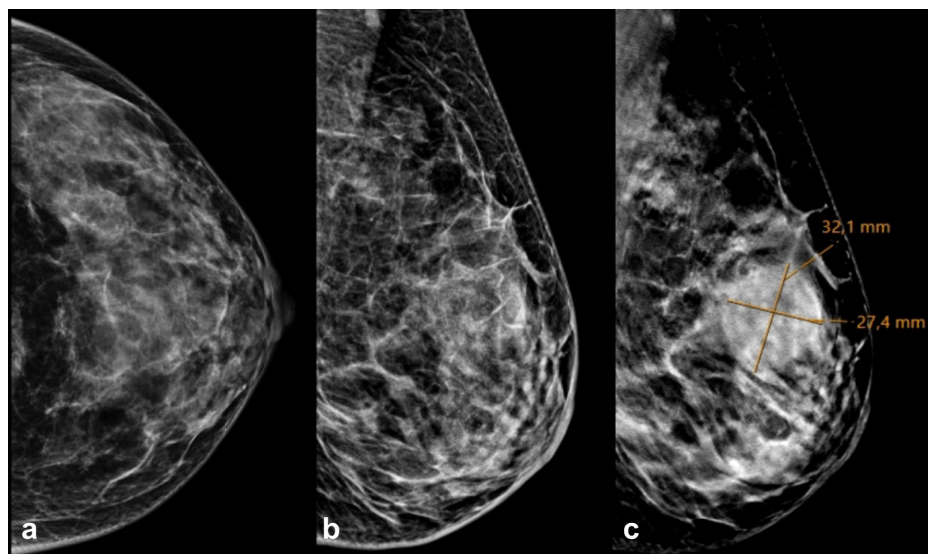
In a 46-year-old female patient who underwent screening MMG, a regional asymmetric density increase was observed in the conventional MMG image at the 12 o'clock position in the left breast, while a 32×27 mm well-circumscribed mass opacity was detected at this level in the DBT images (BI-RADS 3) (evaluated in favor of fibroadenoma by ultrasound). MMG, Mammography; DBT, Tomosynthesis; BI-RADS, Breast Imaging Reporting and Data System.
